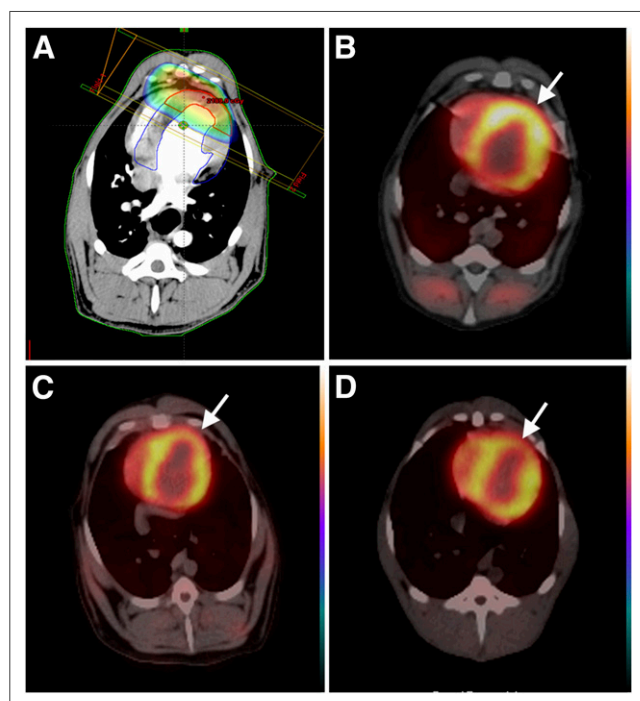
(A) Radiation field and radiation dose distribution. (B–D) PET/CT fusion images showing that scope of perfusion abnormality is consistent with radiation field at 3 mo (B), 6 mo (C), and 12 mo (D) after irradiation (arrows).
